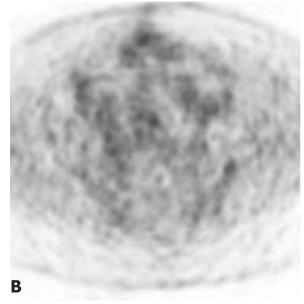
Hemostatic absorbable gelatin (Gelfoam) in a 41-year-old woman who had hysterectomy and bilateral oophorectomy. A, CT shows a very low attenuation lesion (-232 HU) in the surgical bed. Inset shows detail with adjusted window/ level settings. B, PET shows no significant activity.
